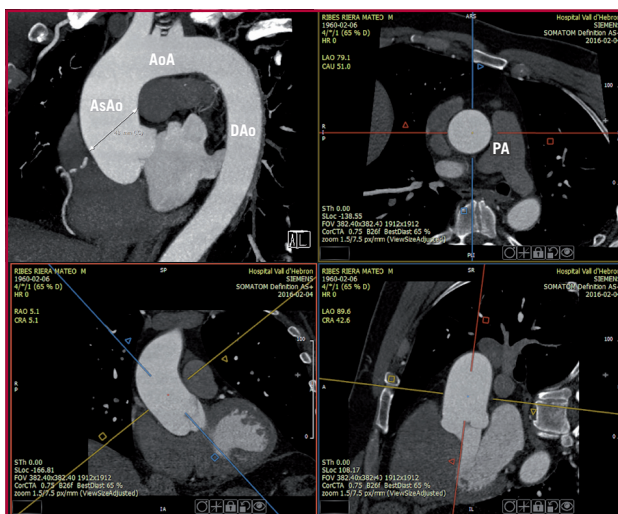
CT angiography of the aorta. Curved multiplanar and double-oblique reconstruction showing accurate measurement of aortic diameters. Oblique measurement of ascending aorta (arrow), overestimating aortic diameters. AsAo (ascending aorta), AoA (aortic arch), DAo (descending aorta), PA (pulmonary artery).
